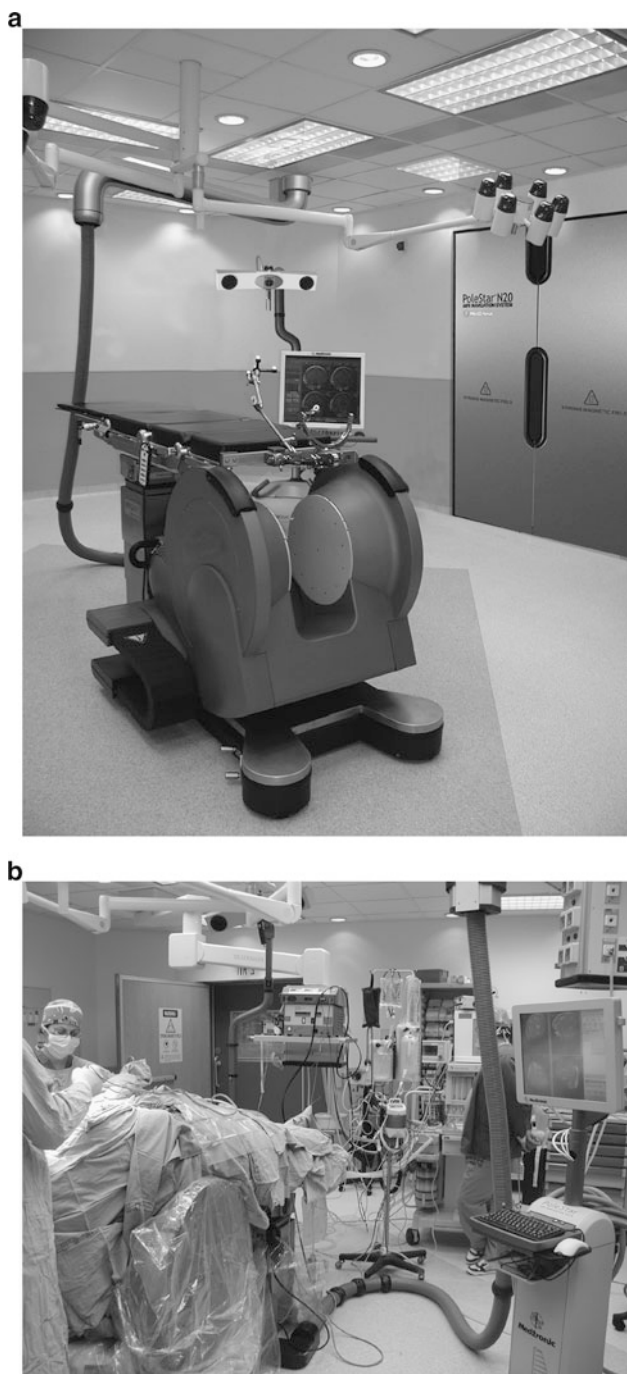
(a) The PoleStar system in a standard operating room shielded for RF. On the right the “cabinet” for the magnet when not in use. The scanner is integrated with the Treon navigation system. (b) Operation room setup. Only anesthesia equipment is MRI compatible
